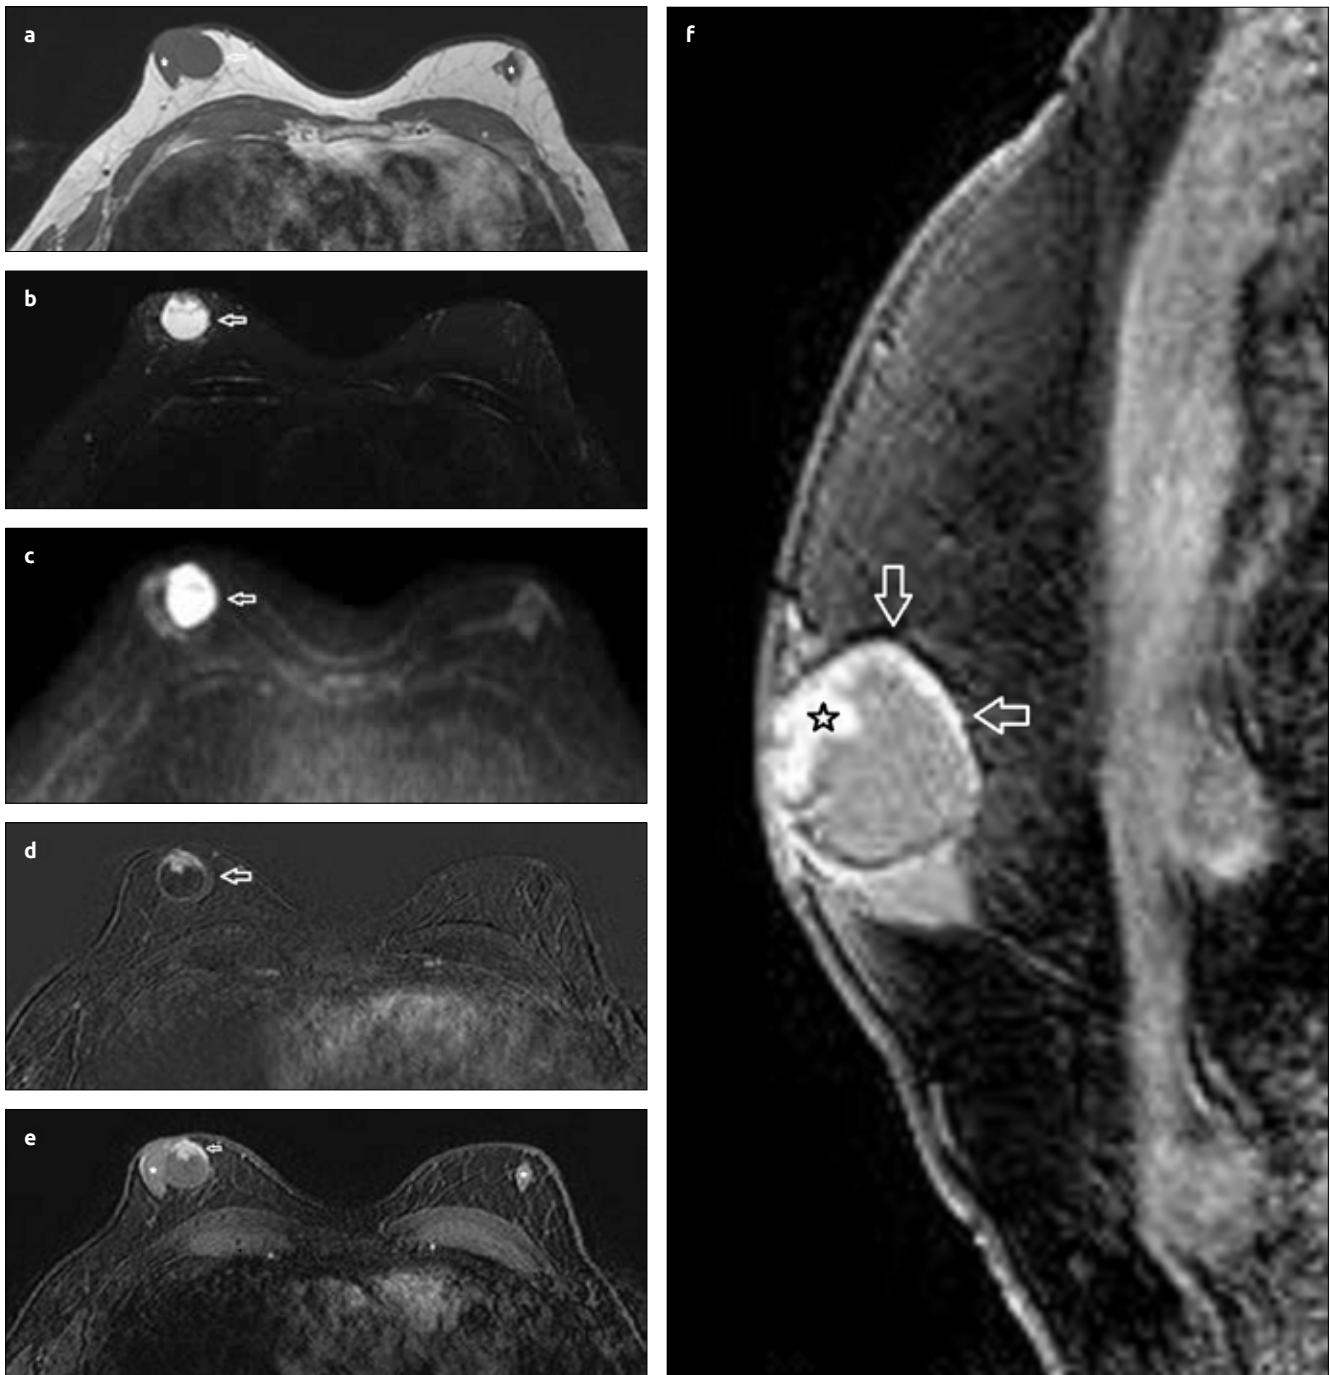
(a-f). a) MR images revealed a circumscribed hypointense mass (arrow) and bilateral hypointense parenchyma (stars) on pre-contrast T1-weighted image (a). Hyperintense complex cystic mass containing hypointense solid component (arrow) was seen on axial T2-weighted image (b). In diffusion-weighted image, the mass shows high signal intensity (c). Axial T1-weighted contrast-enhanced subtraction image showed enhancement of walls of cystic mass and solid nodules (d). Axial post-contrast T1-weighted gadolinium-enhanced image showed mass (arrow) and glandular appearance compatible with gynecomastia (stars) (e). Sagittal post-contrast image showed a circumscribed complex mass with a cystic component and marked enhancing solid nodules (arrows) and peripheral wall (star) (f)
